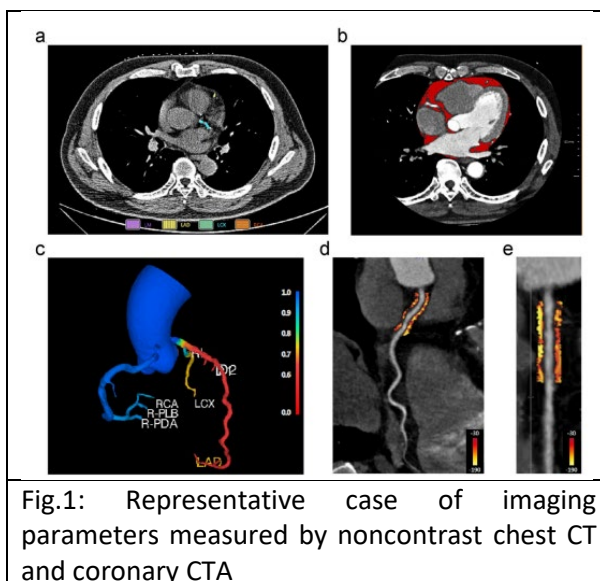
Representative case of imaging parameters measured by noncontrast chest CT and coronary CTA
